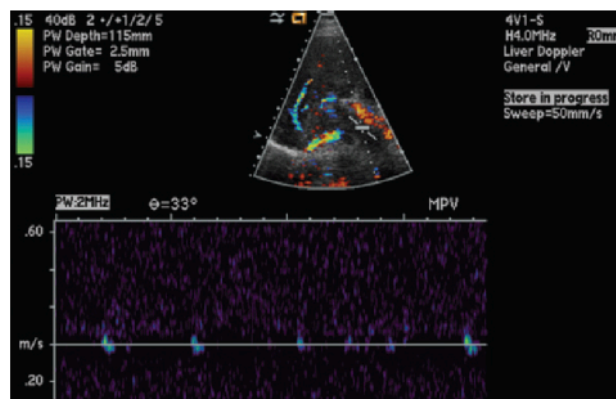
Portal vein thrombosis (acute bland thrombus). On a spectral Doppler US image, the interrogation zone shows no color flow in the main portal vein. The spectral waveform is aphasical, which indicates absence of flow. An aphasical waveform may be produced by either obstructive or nonobstructive disease.
